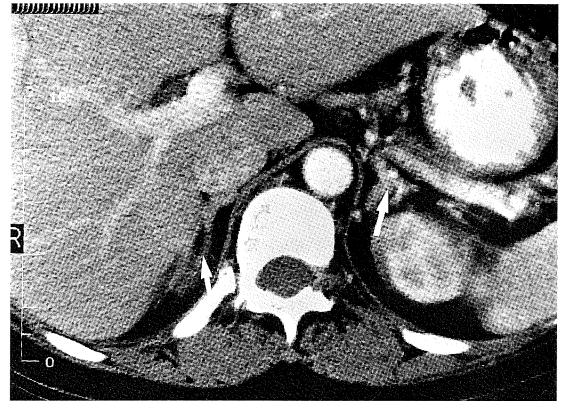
CT scan of the adrenals (3 mm section) showing both adrenal glands to be of normal size and configuration (arrows).
